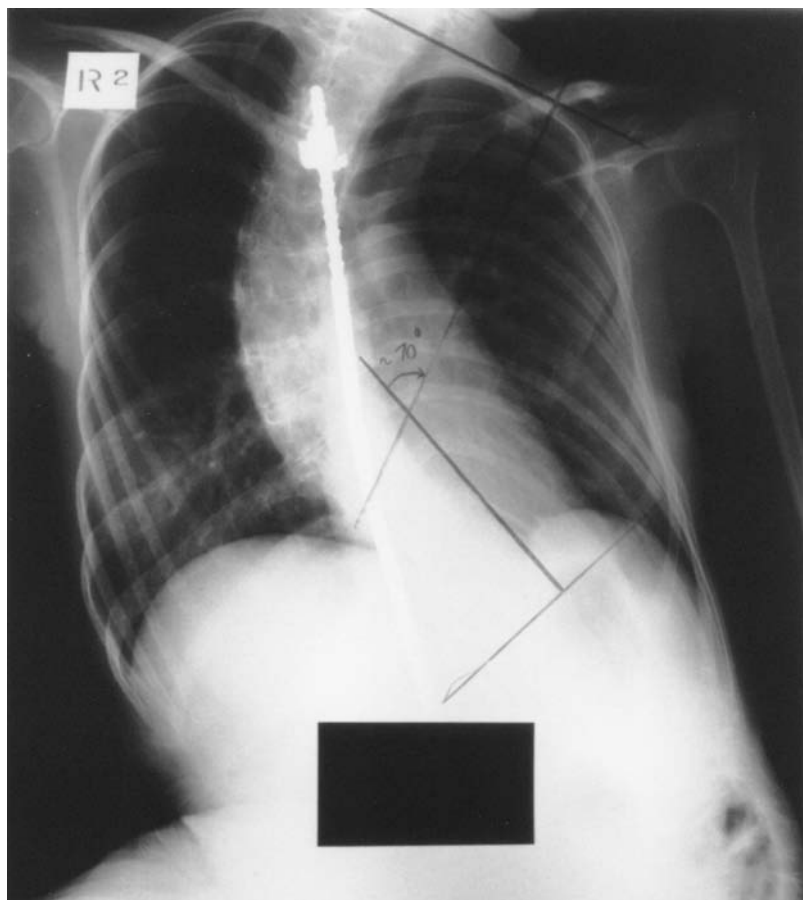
Cobb angle – chest x-ray. Cobb angles are represented on this x-ray of a young woman with a progressive spinal muscular atrophy (Kugelberg-Welander syndrome) and a 70° thoracic curve. Note should also be made of the rib separation on the right hemithorax compared with the left. This patient’s pelvic film is detailed in Figure 7.6.
